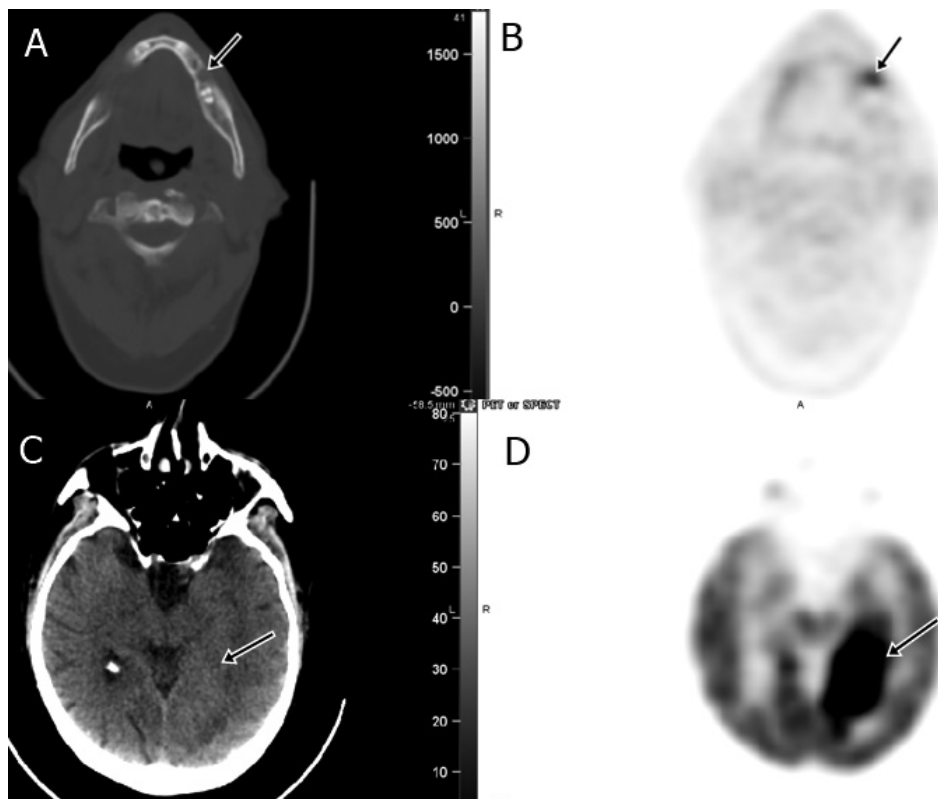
A 76-year-old man four months following chemotherapy for diffuse large B-cell lymphoma of the left mandible (patient 7). (A and B) Restaging FDG PET/CT showed improvement of the primary lesion (arrows), but there was a large (C and D) FDG avid metastatic mass in the left cerebellum (arrows), which was verified by MRI and surgical pathology. FDG, fluorodeoxyglucose; PET, positron emission tomography.
